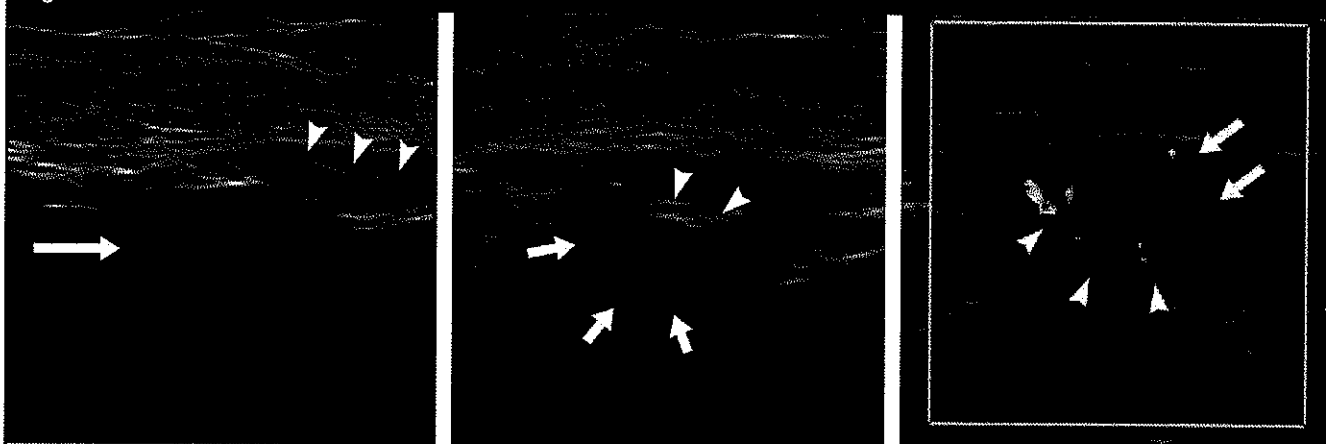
(a, b) Standard and (c) color Doppler axillary lymph node US images show three abnormal US findings (in three different patients). (a) Oval hypoechoic lesion (arrow) represents lymph node with absence of fatty hilum adjacent to normal lymph node with normal fatty hilum (arrowheads). (b) Lymph node with asymmetrically thickened cortex (arrows) and diminished fatty hilum (arrowheads). (c) Hilar blood flow (arrowheads) and NHBf (arrows) to the cortex at the periphery.
